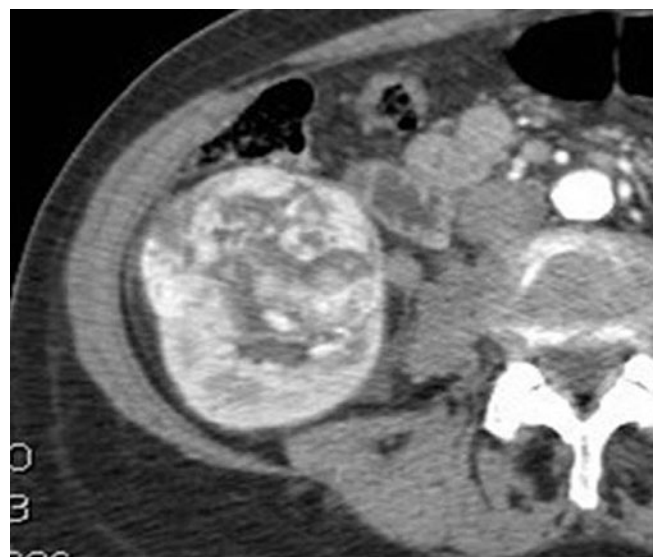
Clear cell renal cell carcinoma (RCC). Contrast-enhanced computed tomography (CT) image during the corticomedullary phase (CMP) demonstrates a heterogeneously and briskly enhancing right renal mass, consistent with a clear cell RCC
